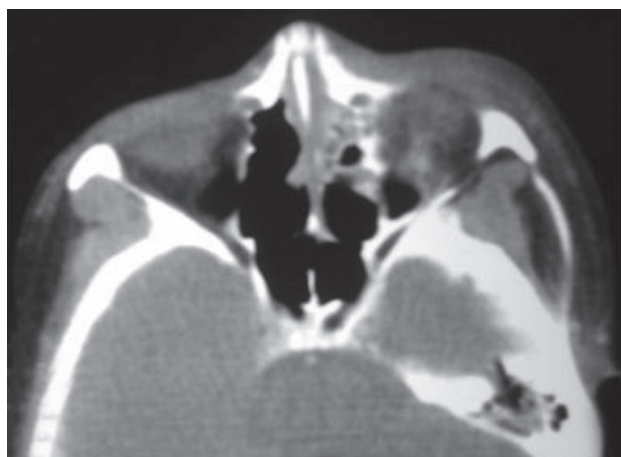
Computed tomography scan nose and paranasal sinus axial section showing soft tissue thickening in left nasal cavity and maxillary sinus with bony erosion
